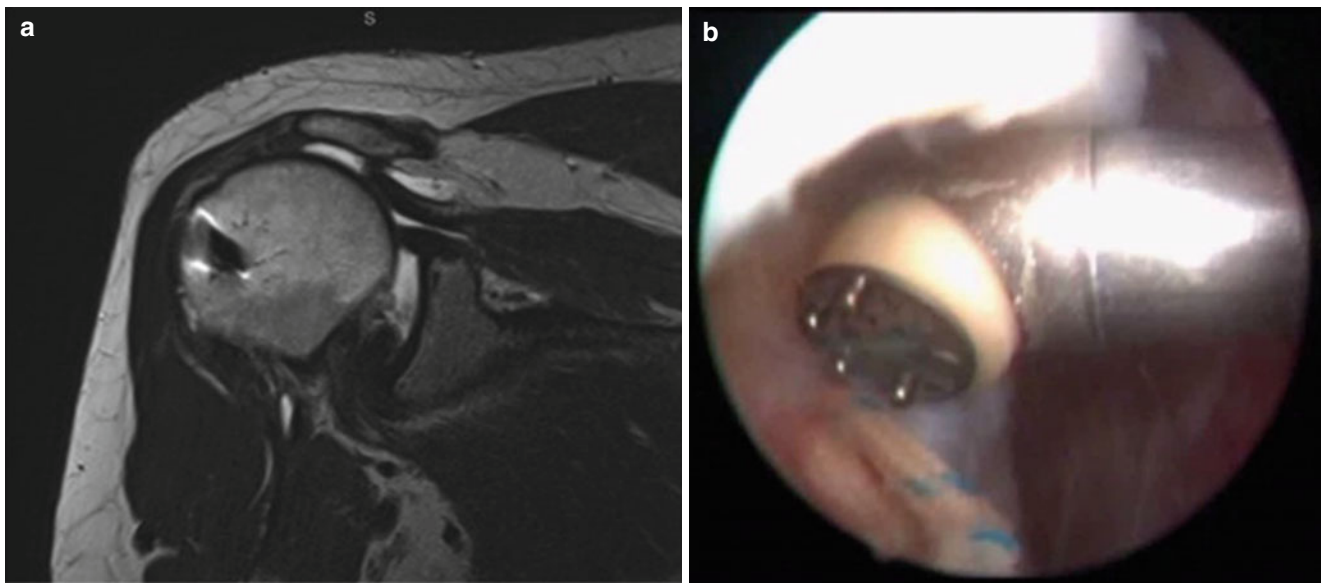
Right shoulder of a 67-year-old gentleman. MRI scan (a) and arthroscopic view (from the posterior portal) (b) showing a rotator cuff repair failure
